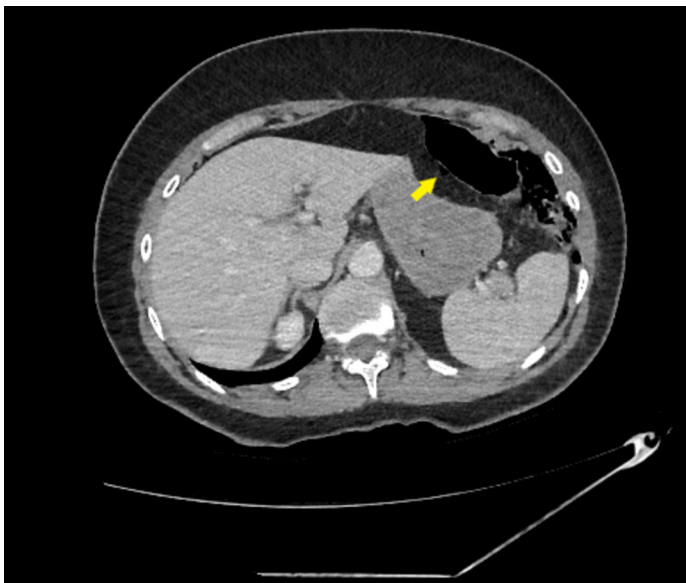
A yellow arrow indicates the free air inside the transverse colon wall on a computed tomography scan
